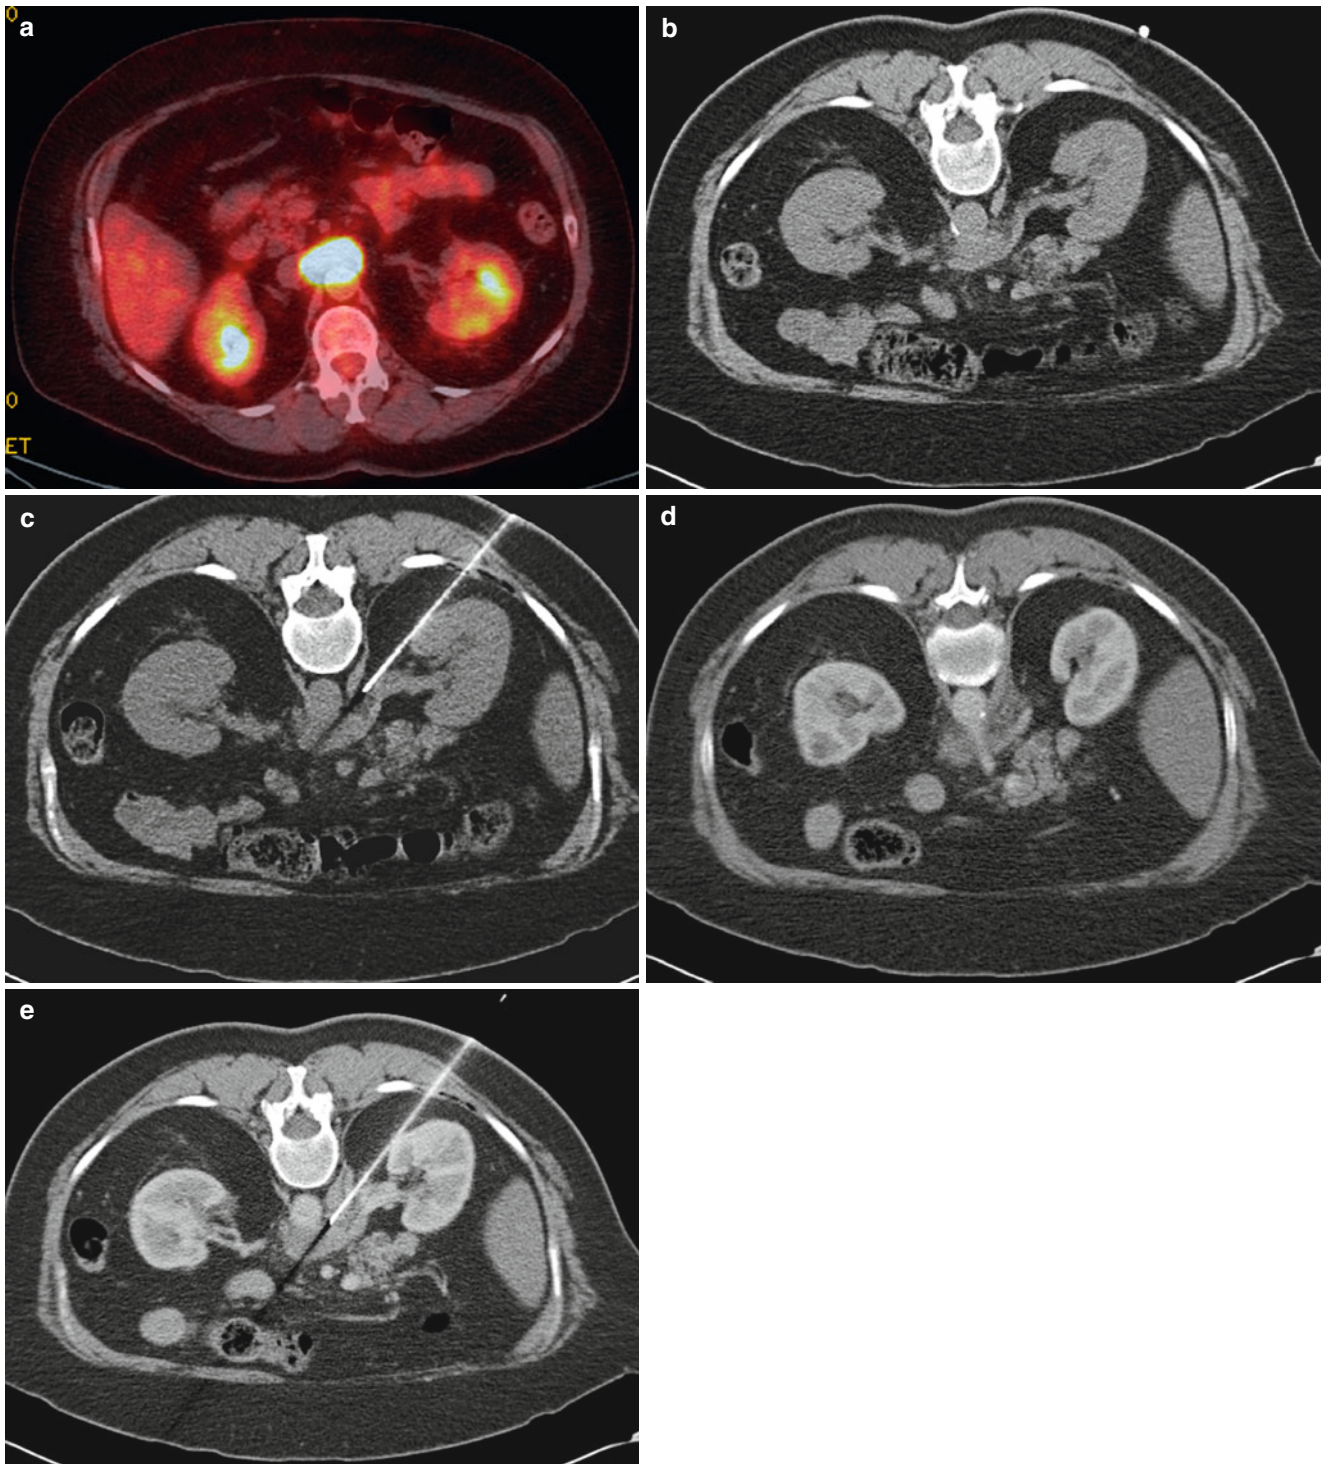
A 62-year-old woman with lymphoma underwent resting PET/CT examination. Axial fused PET/CT image of the abdomen (a) shows a metabolically active soft tissue mass encasing the celiac axis. Noncontrast axial CT image of the abdomen in prone position (b) shows the soft tissue mass abutting the anterior wall of aorta. A guide needle was advanced to the edge of the lesion (c). Immediately before
